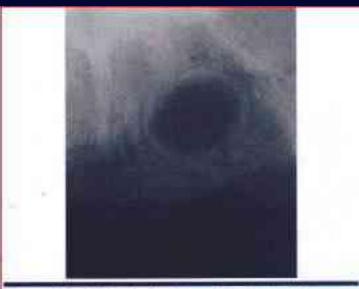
• Residual periapical cyst, Persistent radiolucency of the mandibular body at aite of previous tooth estraction.
